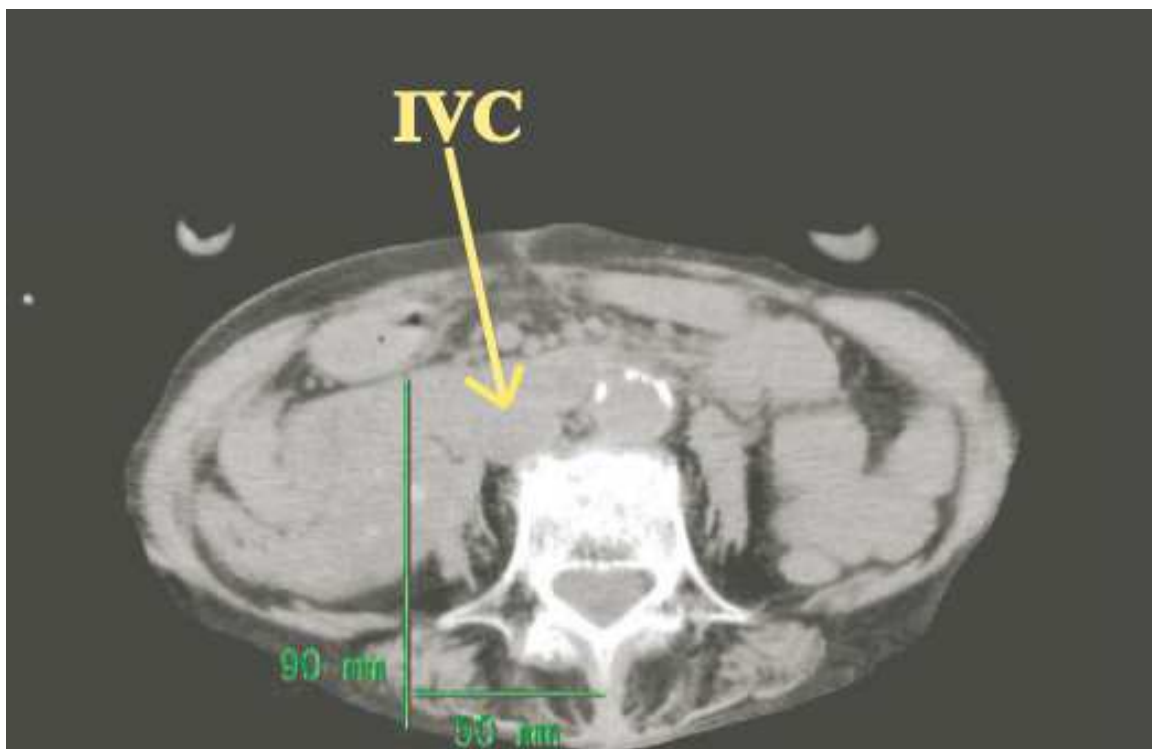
The computed tomography at the 4th lumbar spine level from a 90-year-old female. Inferior vena cava is distended (indicated by the arrow), and there is a potential risk of inadvertent inferior vena cava puncture in this case.
